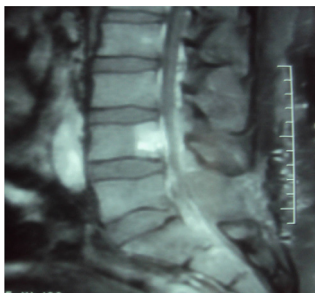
Sagittal T2-weighted Magnetic Resonance Image (MRI) showing a solid epidural mass at the L5-S1 levels with homogeneous enhancement.
